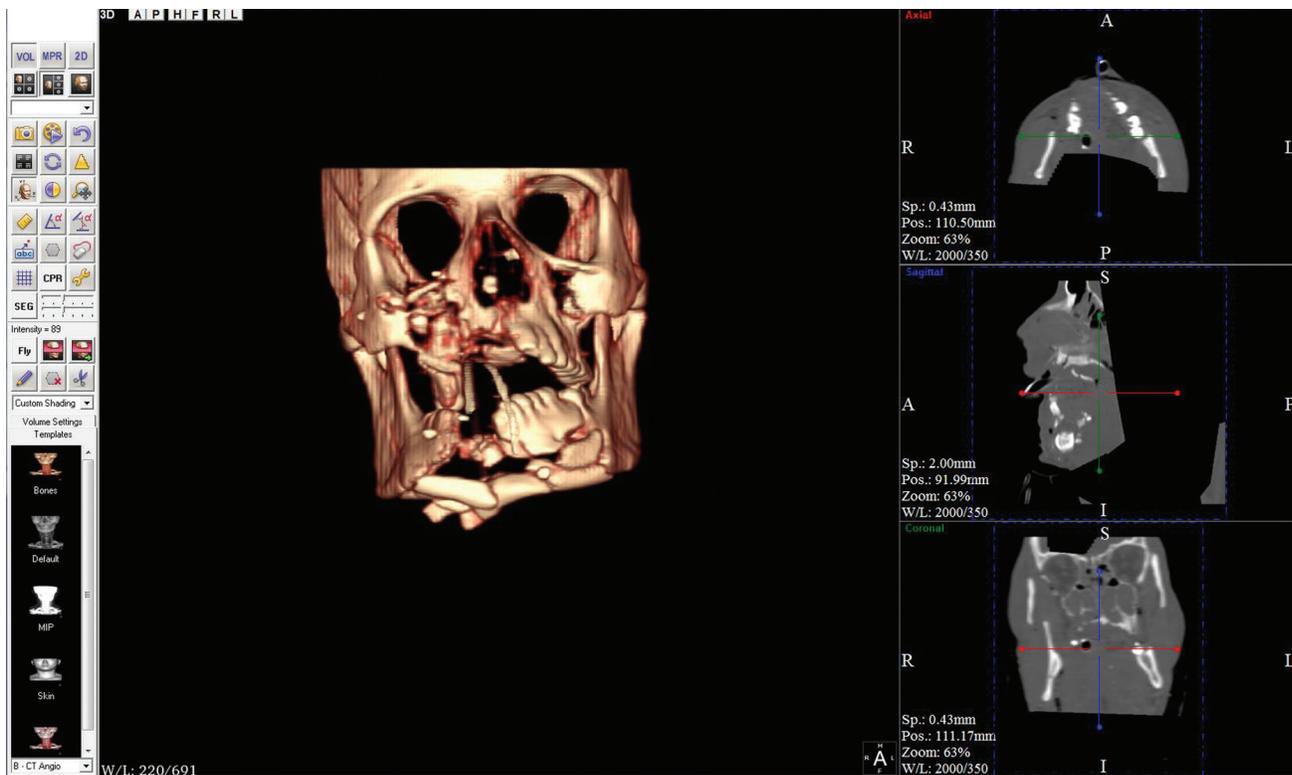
(a). Preoperative computed tomography scan.
